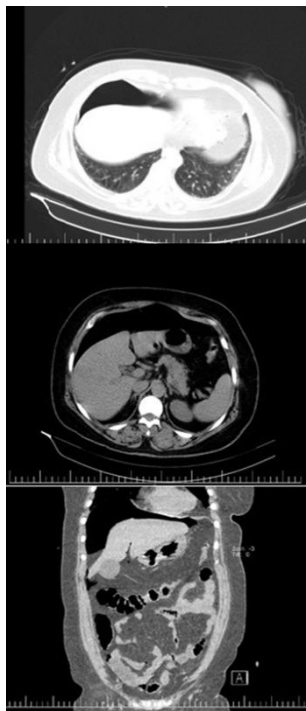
Abdominal CT scan shows sub diaphragmatic air pattern (pneumo peritoneum)
